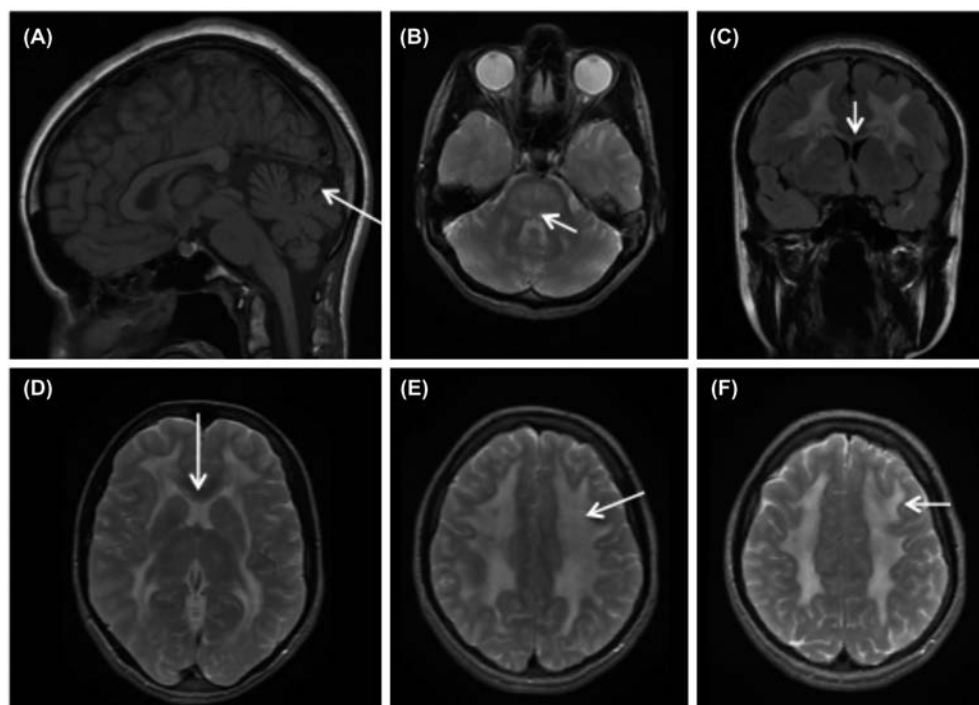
Brain MRI findings in MNGIE. MRI of MNGIE patient at age 16 with “typical” MNGIE phenotype. (A) T1 weighted sagittal image shows cerebellar vermis atrophy (arrow) and normal gyral pattern. (B) Axial T2 with hyperintensities in the dorsal pons and mesencephalon (arrow). (C) coronal flair image, (D) axial T2) show extensive signal abnormalities in the cerebral white matter. The external capsule is involved as is the inner blade of the corpus callosum (arrow C, D). (E, F) Extensive white matter involvement with sparing of the U-fibers (arrow).
